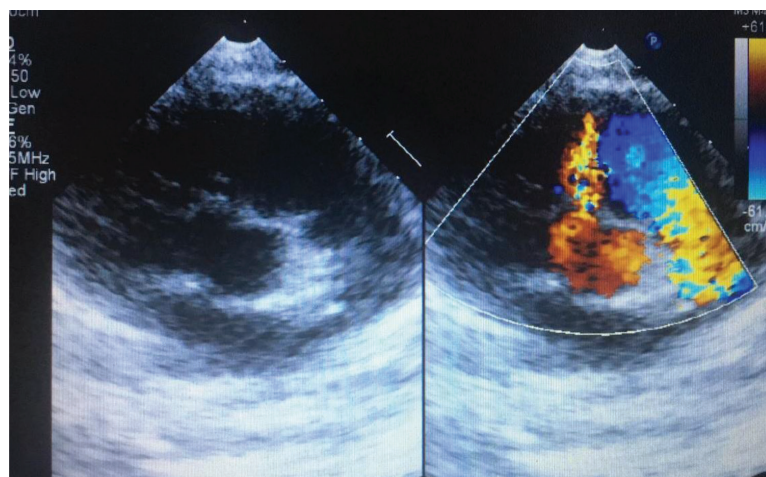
Echocardiography: Left to right shunt at VSD level
